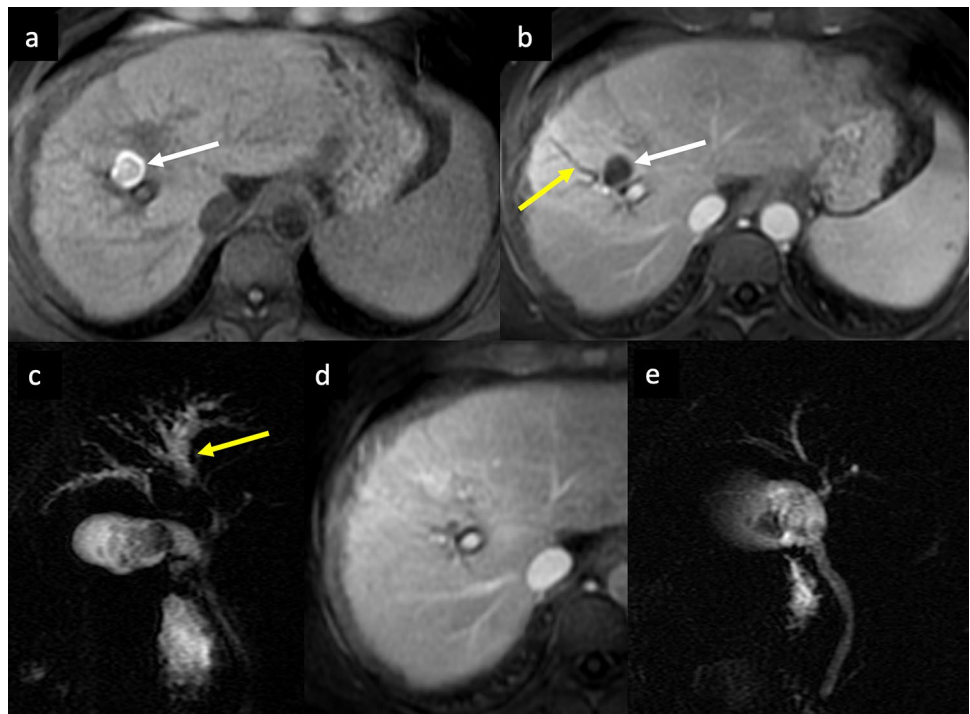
Liver hematoma. MR imaging shows a hepatic hematoma (white arrows) hyperintense on a T1-weighted image (a) and non-enhancing in a contrast-enhanced portal venous phase image (b). The hematoma causes biliary dilatation (yellow arrows), better visualized on a coronal MRCP image (c). Some months later, axial contrast-enhanced MR (d) and coronal MRCP (e) images show hematoma regression with a reduction in biliary dilatation
